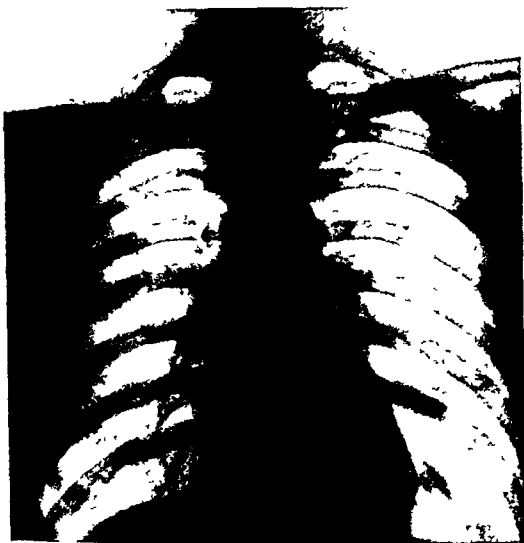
W R Routine film of the chest which was taken before laryngectomy was performed. The roentgenogram discloses no abnormalities.
